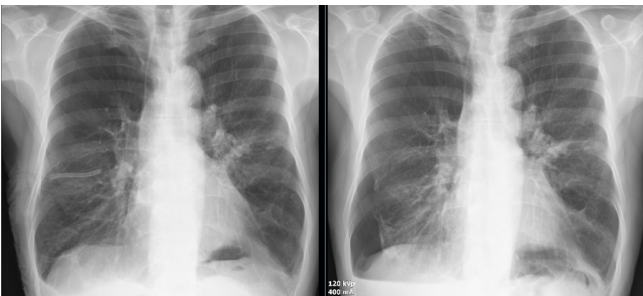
Right-sided pneumothorax: pre- and post-catheter insertion chest radiographs
